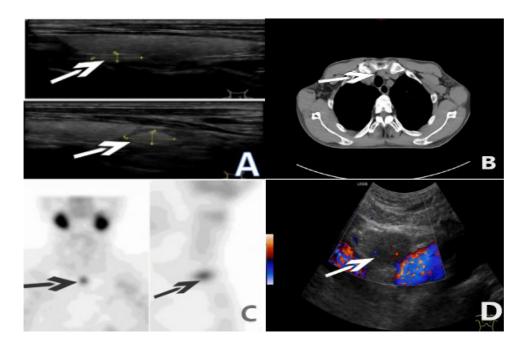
Imaging findings of ectopic parathyroid hyperplasia in the upper mediastinum. Ultrasound images of 2 of the patient's normal parathyroid glands (A). Chest CT showed nodules of ectopic hyperplasia in the superior mediastinum (B). Nodule with radioactivity in late phase of MIBI scan (C). Color Doppler ultrasound showed nodules of ectopic hyperplasia adjacent to large vessels (D).
